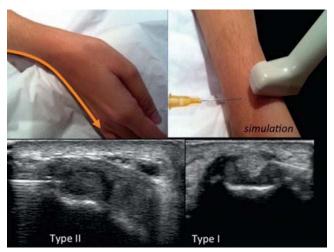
Position of the patient and axial approach for injection of a de Quervain's tenosynovitis. Needle in place in a patient in whom the abductor pollicis longus and extensor pollicis tendons are separated by a septum (Type II de Quervain's tenosynovitis on left of image). Ultrasound-guided needle placement into the extensor pollicis tendon subcompartment, and under the retinaculum in a patient in whom the tendons are not separated by a septum (Type I de Quervain's tenosynovitis on right of image) (From Vuillemin HG, Morvan G. Musculoskeletal interventional ultrasonography: the upper limb. *Diagn Interv Imaging*. 2012;93(9):665–673.)
